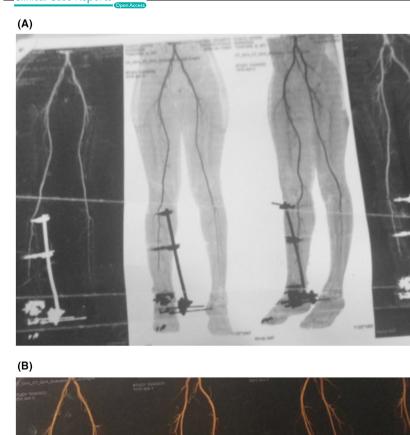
(A, B) CT angiography images showing occlusion of the right posterior tibial artery at the fracture site.
